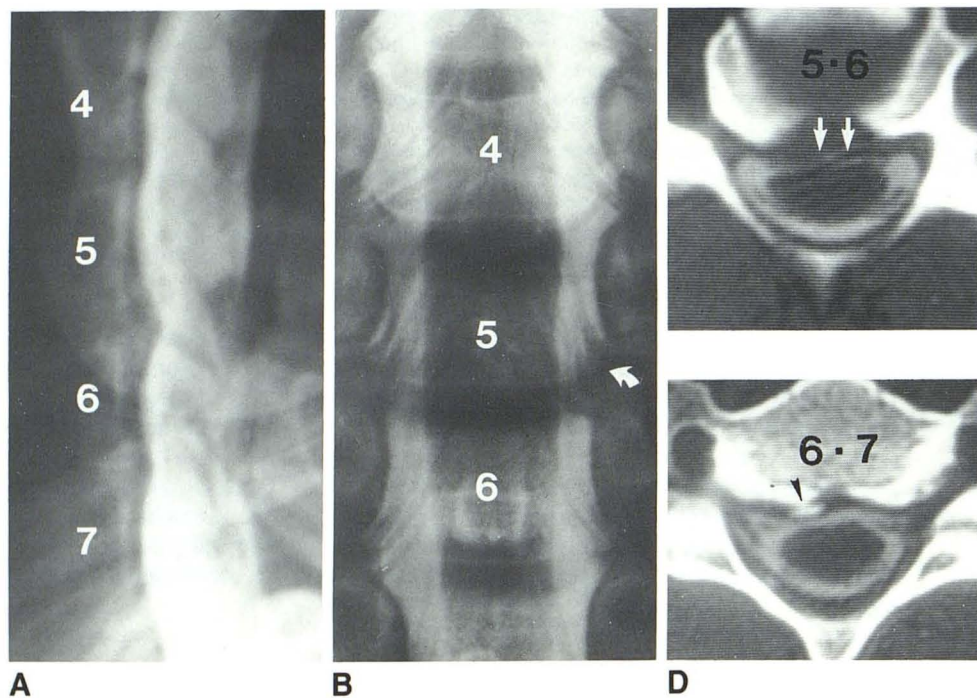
37-year-old man with neck pain radiating into right hand. There was hypalgesia in C5–C6 and C6–C7 dermatomes and loss of right biceps reflex. A, Lateral myelogram. Large C5–C6 ventral defect with smaller lesion at C6–C7. B, Frontal view. Minimal root sleeve changes at C5–C6 (arrow). C, Axial CT myelogram at C5–C6. Diffuse central soft disk herniation with cord deformity. Ventral subarachnoid space is nearly obliterated (arrows) and dorsal space is spared. D, At C6–C7. Focal spondylotic spurring (arrowhead) on right with compromise of ventral space. Degree of C6–C7 disease was not appreciated on conventional myelogram. Patient underwent anterior C5–C6 and C6–C7 discectomy. There was a soft disk herniation at C5–C6 and large osteophyte on right at C6–C7. He had resolution of pain, and some improvement in sensation. Biceps reflex remained silent.
